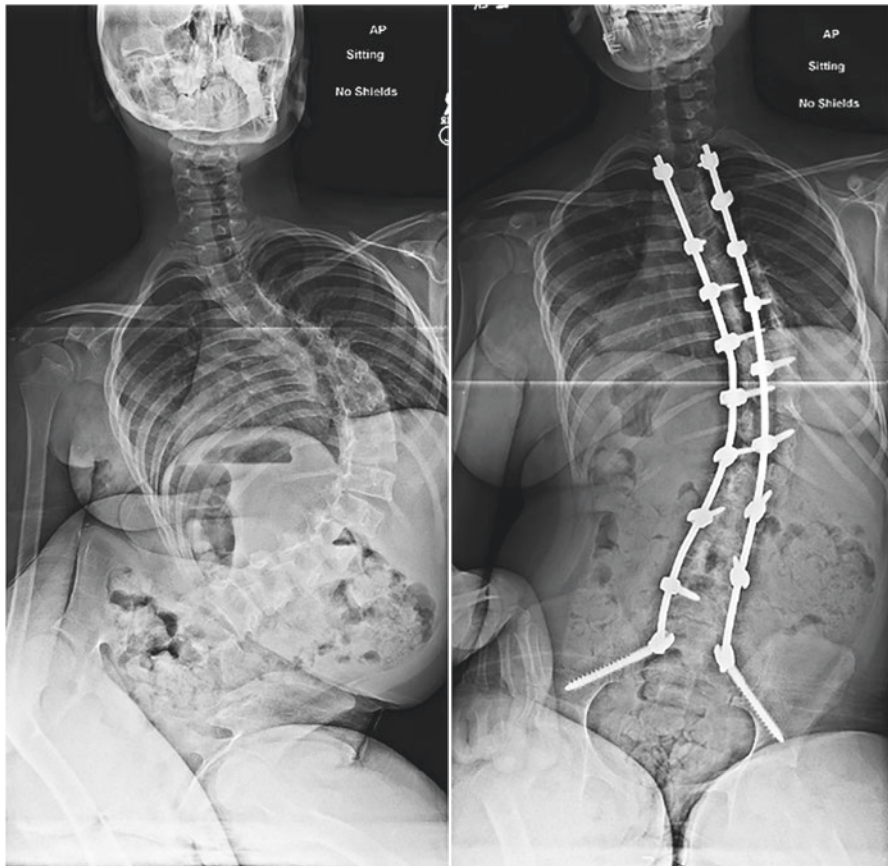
Pre- and post-operative AP radiographs of a non-ambulatory patient with cerebral palsy treated with an instrumented posterior fusion to the pelvis
